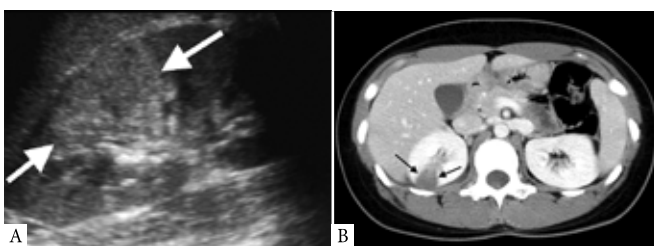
Longitudinal US scan of the kidney showing at segmental area of hyperechogenicity (arrows) that correlates with focal nephritis. b. Contrast-enhanced CT scan showing a segmental area of hypoperfusion (arrows).
